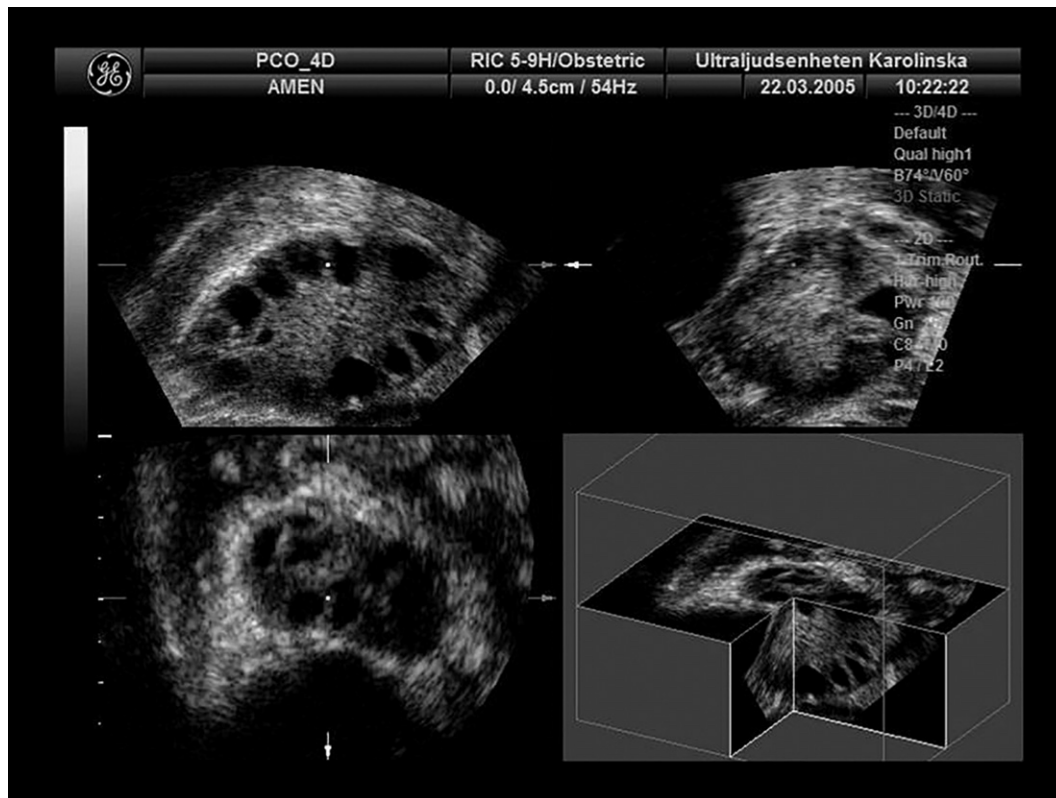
Ultrasound picture of a typical enlarged polycystic ovary with an increased number of small follicles.
